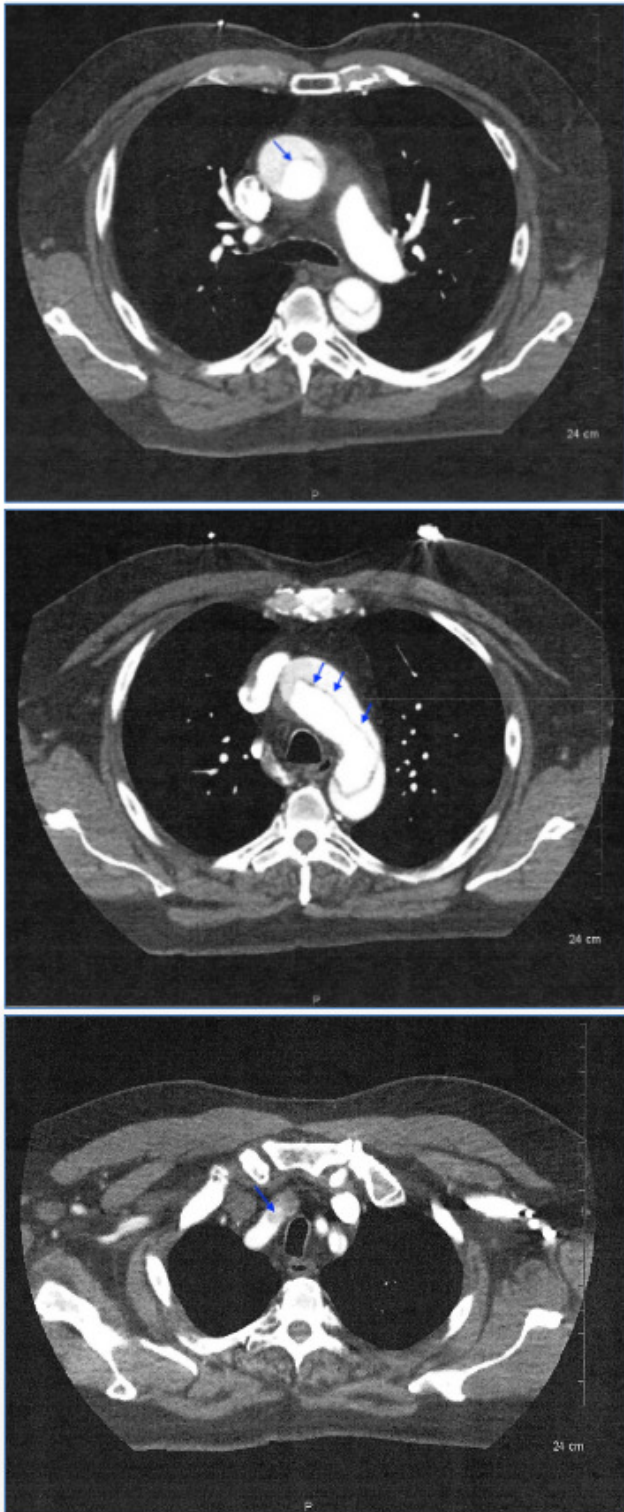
Axial CT scan images demonstrating extensive aortic dissection (blue arrows)
